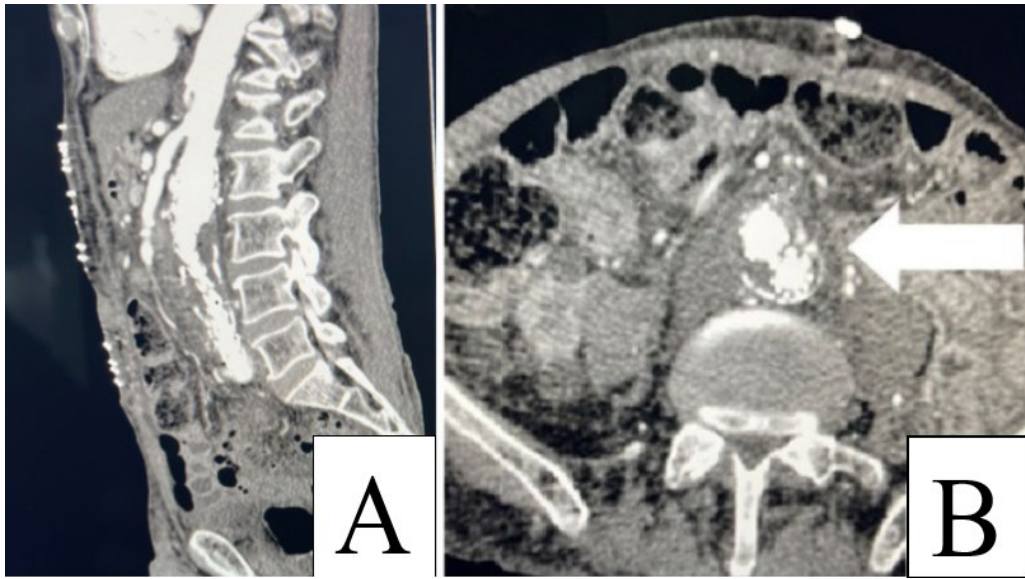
Contrast-enhanced computed tomography images five years after EVAR. (A) Sagittal reconstruction and (B) axial images of the aneurysm sac 64 mm. Hyperattenuating foci seen within the aneurysm sac indicate the presence of endoleak (arrow).
